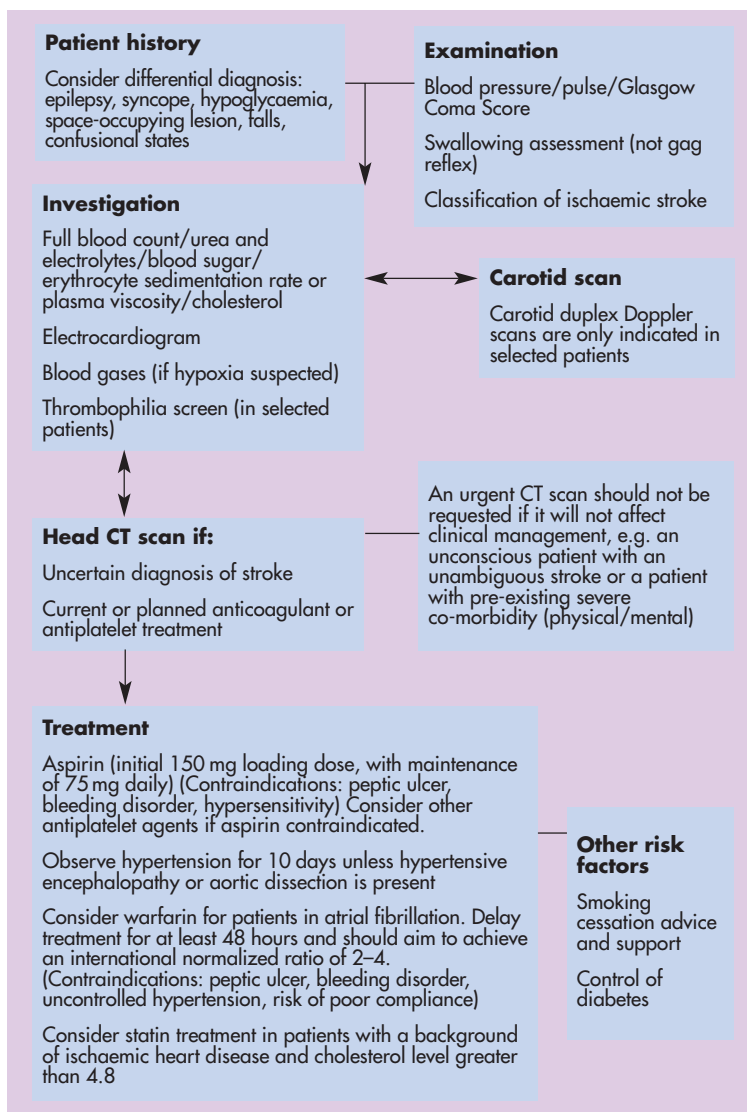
Summary of clinical guidelines for early management of stroke. CT = computed tomography.
